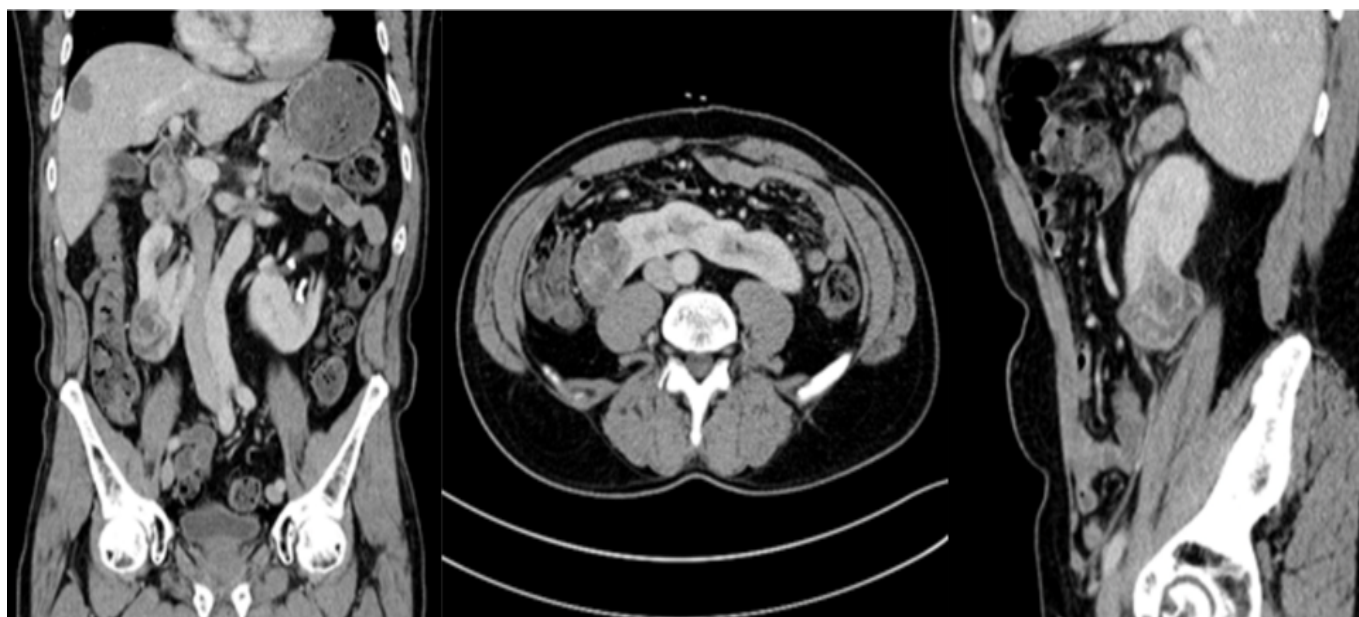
Contrast enhanced abdominopelvic CT in venous phase. Coronal reconstruction (left), axial reconstruction (middle), sagittal reconstruction (right) showing a 54/43/51-mm mass in the right moiety.
